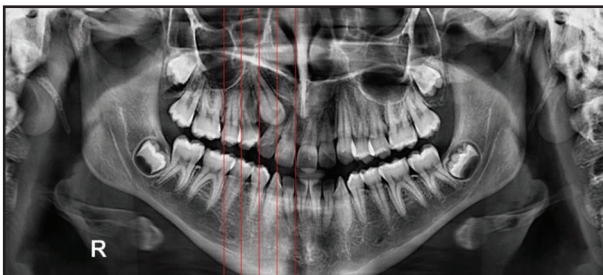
Panoramic radiograph showing mirroring of the constructed vertical sectors on impaction side
